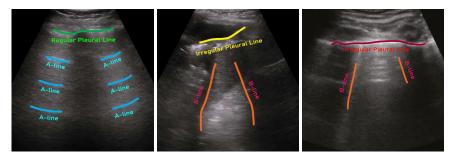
Demonstration of different types of lines that may appear in lung ultrasound images. A-lines are marked with blue, B-lines are marked with yellow, and the pleural line is marked with green [12].
